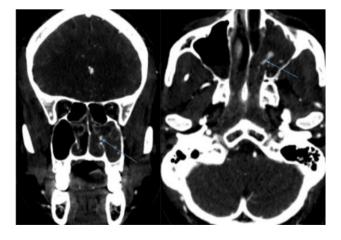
CT angiogram shows active extravasation of contrast into the of left maxillary hemo sinus is noted.
